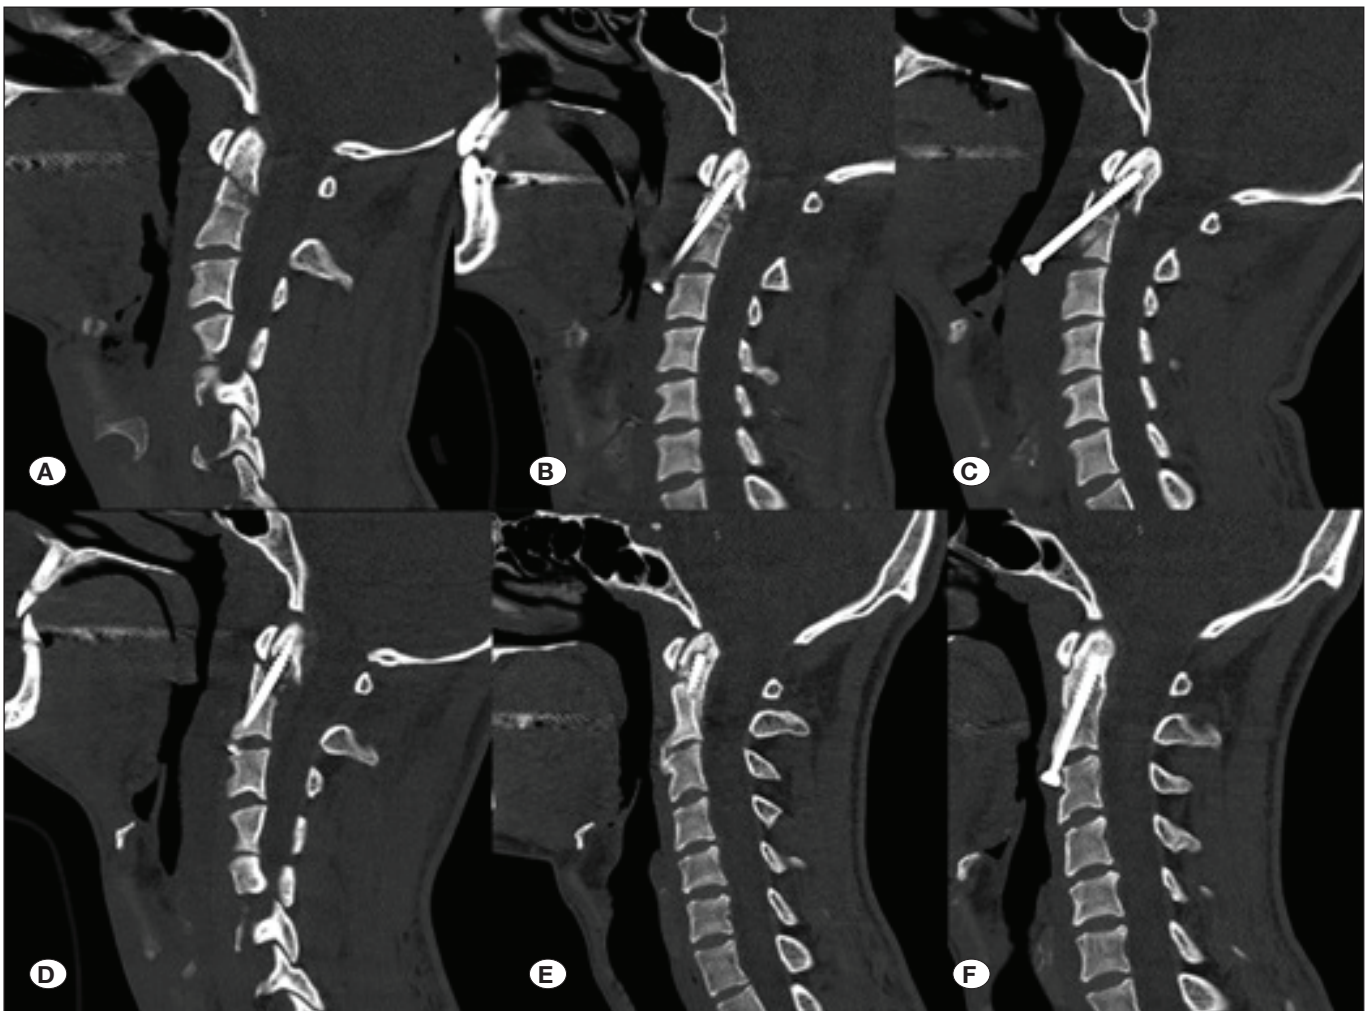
Sagittal plane cervical CT images of the patient who underwent revision surgery: A) Preoperative, B) postoperative 1st day after the 1st operation, C) postoperative 3rd day after the 1st operation (after the development of dysphagia), D) postoperative 1st day after revision surgery, E) postoperative 3rd month after revision surgery, F) postoperative 1st year after revision surgery.
